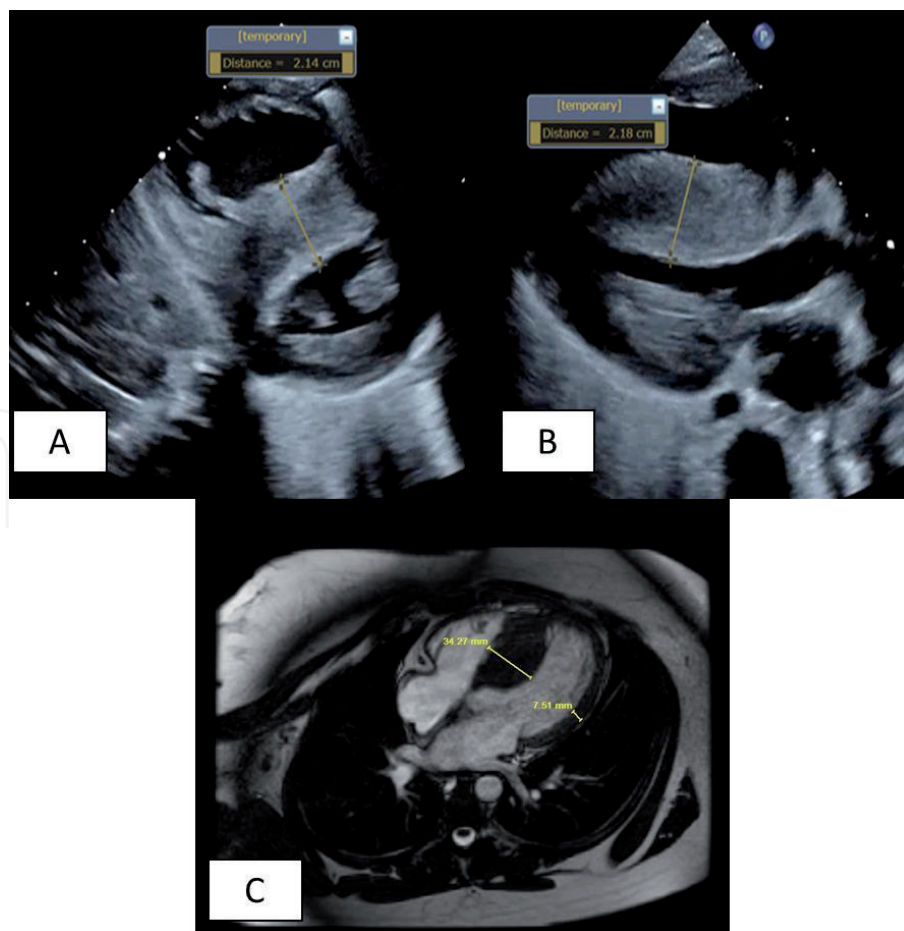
Two dimensional images of HCM in the parasternal short axis (A) exhibiting concentric hypertrophy with significant involvement of the interventricular septum (IVS) and corroborated by the parasternal long axis view (B). Cardiac MRI also shows significant thickening of the IVS (C).
